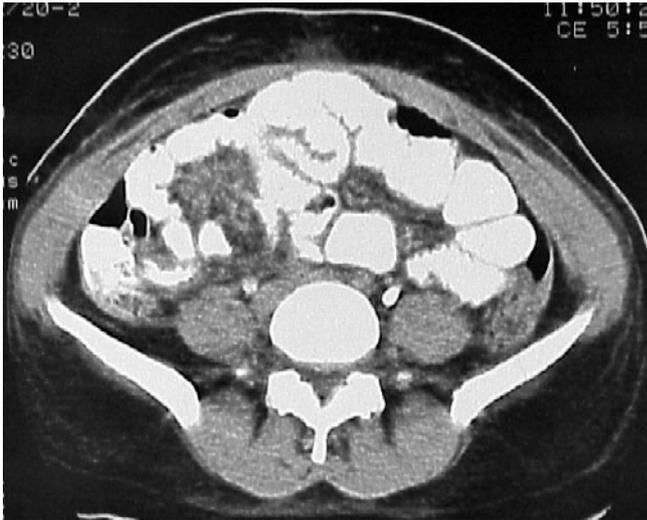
Abdominal CT scan in patient 2 showing irregularity and mural thickening in terminal ileal loop and cecum.
